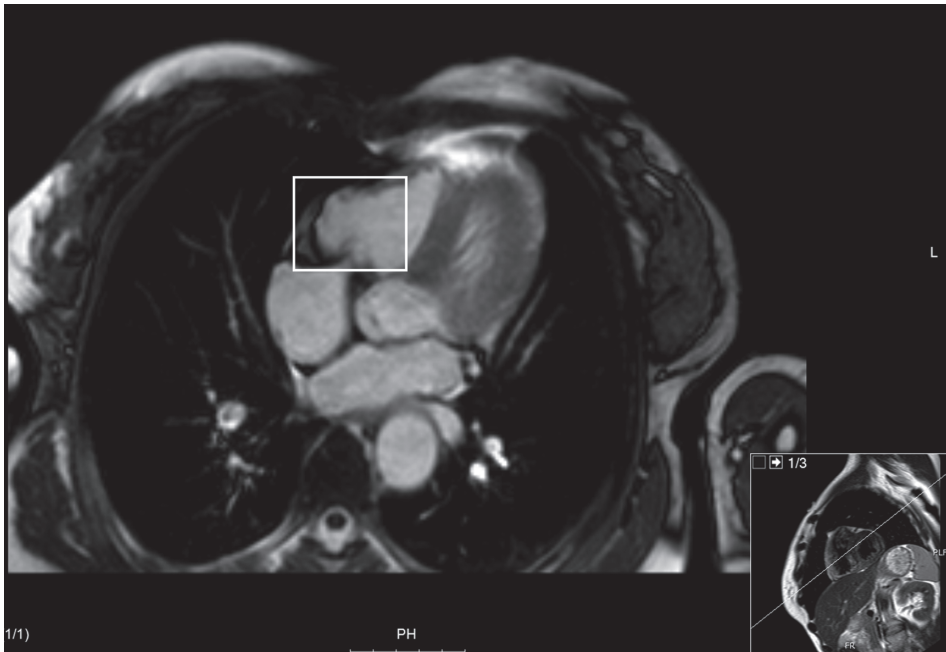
Cardiac magnetic resonance imaging of the patient of whom data are depicted in Figures 2 and 3 (patient 1, see Table 2), showing a dyskinetic wall motion abnormality in the subtricuspid area (indicated by the white frame). These abnormalities correlate well with the induced ventricular tachycardia morphology (Figure 2) and electrical abnormalities found inferior of the tricuspid valve (Figure 3).
